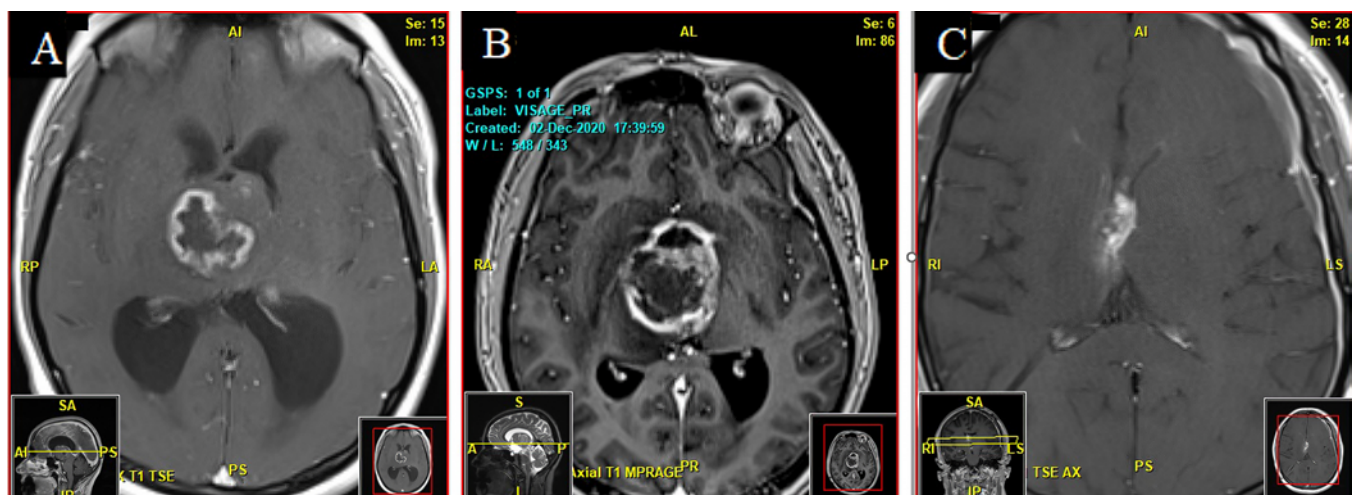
A: Axial MRI section obtained at initial presentation. B: Axial MRI section showing radiographic deterioration following presentation. C: Axial MRI section obtained postdebulking.
